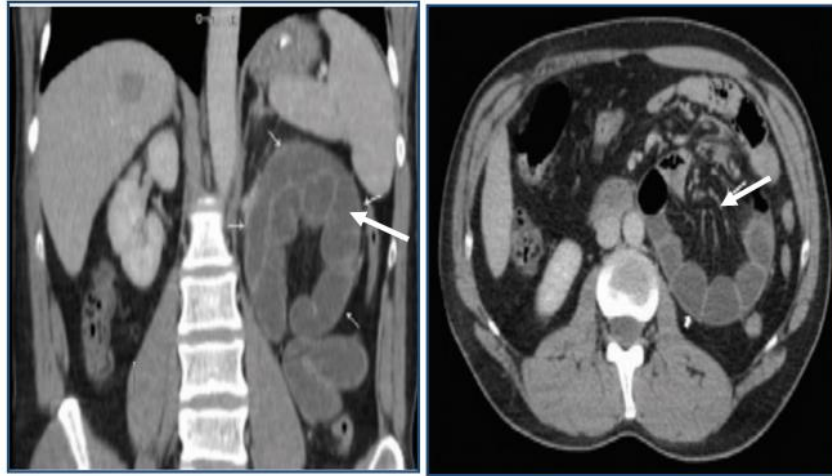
CT Abdomen photograph showing left paraduodenal hernia with intestinal obstruction
